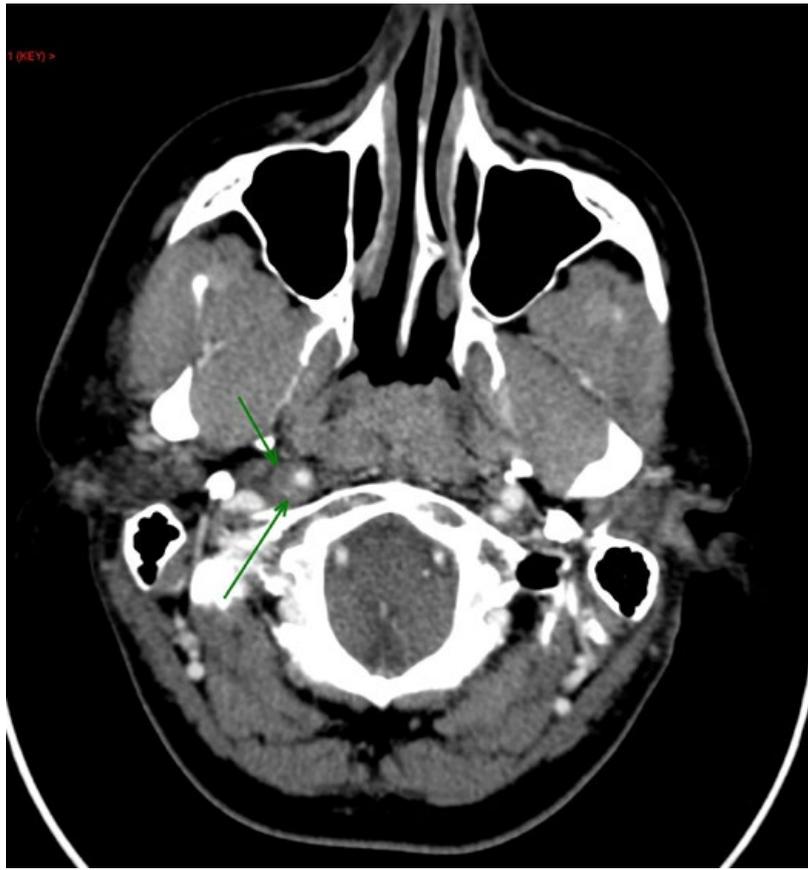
Axial CT image depicting the intramural haematoma.
